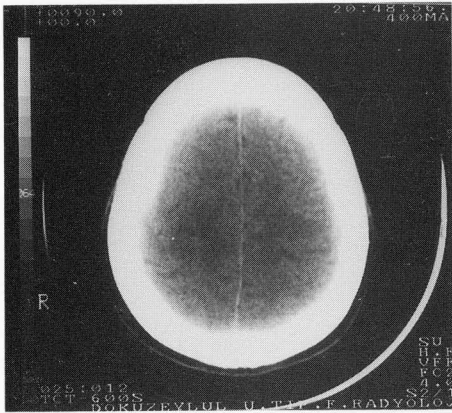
CT scan taken on admission.
